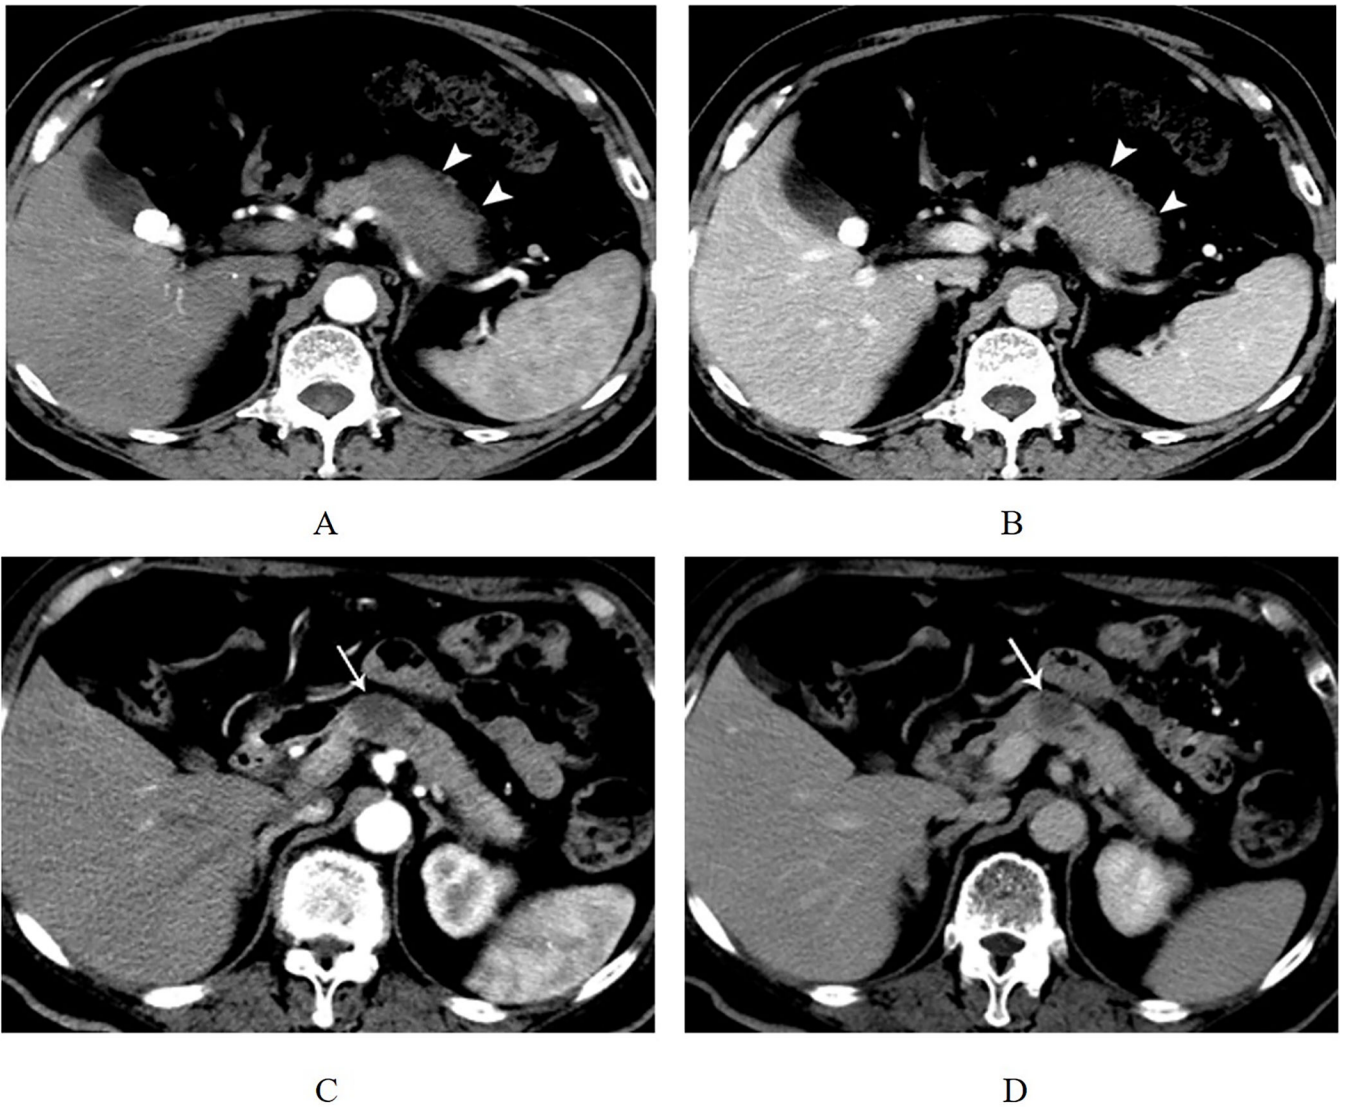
Typical CT Features of focal-type autoimmune pancreatitis and pancreatic adenocarcinoma.
